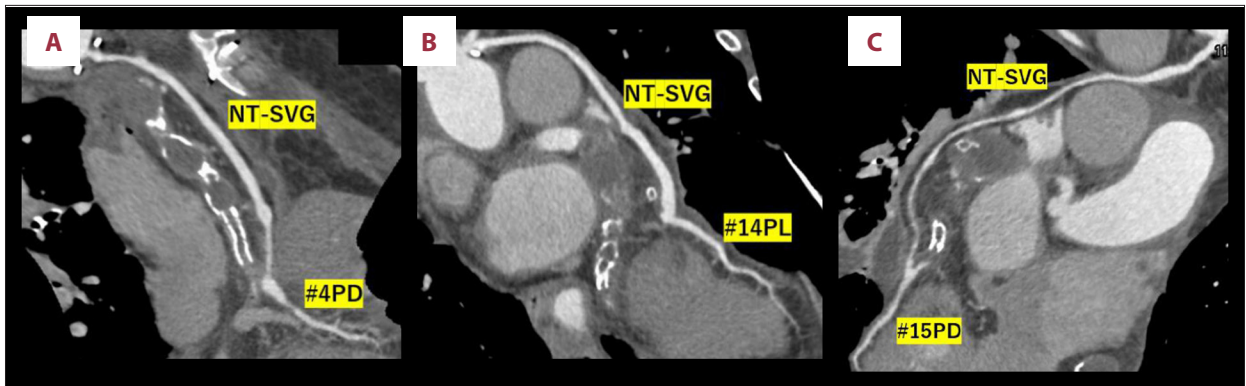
Coronary computed tomography angiography (CCTA) images of the bypass grafts on postoperative day 8. Curved multi-planar reconstruction of CCTA images show the good patency of saphenous vein grafts, harvested using the “no-touch” technique, in the right coronary artery (A) and the left circumflex artery (B, C). #4PD: posterior descending branch of the right coronary artery, #14PL: posterolateral branch of the left circumflex artery, #15PD: posterior descending branch of the left circumflex artery.
